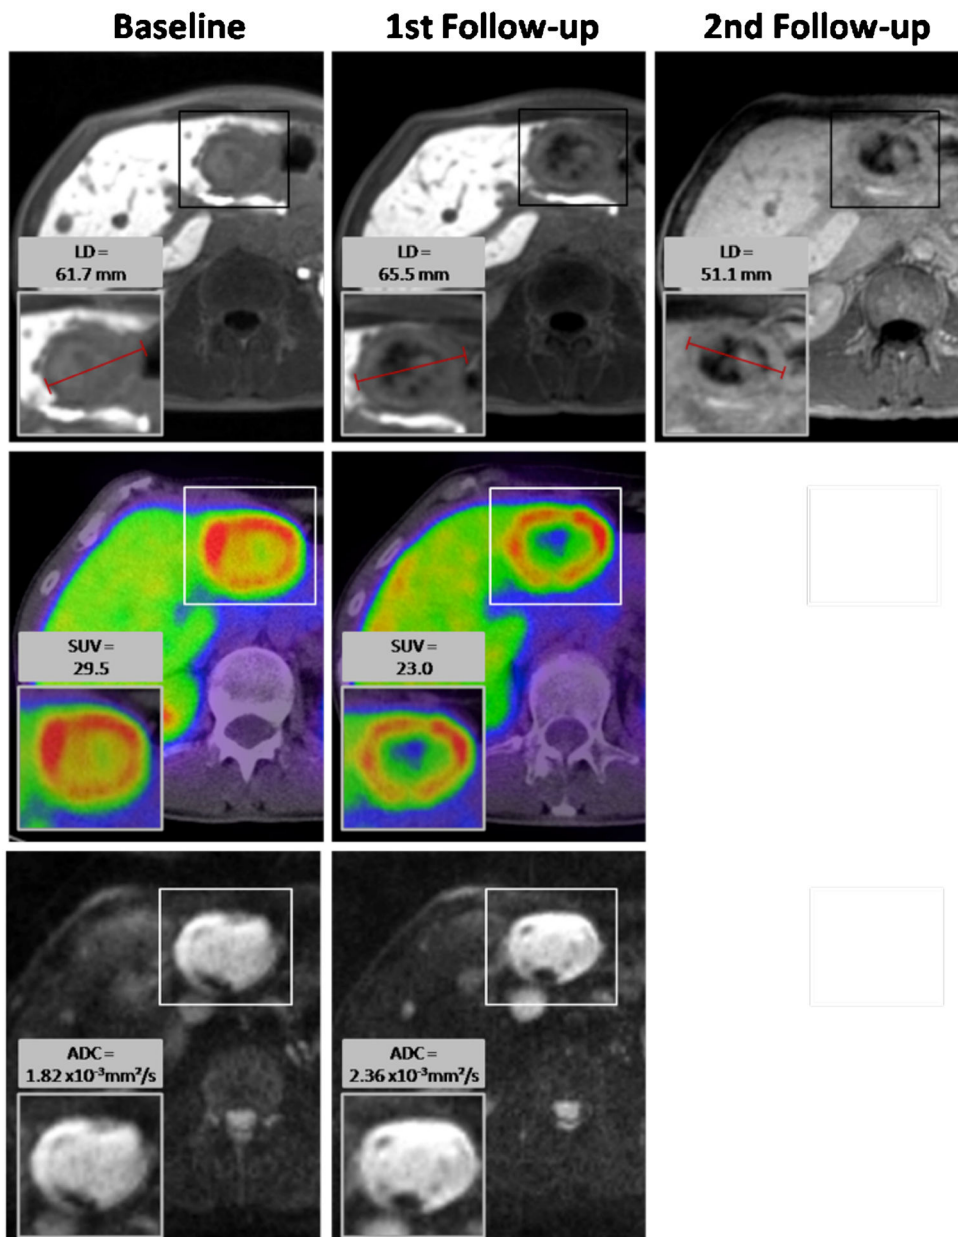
Neuroendocrine liver metastasis in a 44-year-old male. After one cycle of PRRT (first follow-up), the LD and the volume of the target lesion increased and it was thus categorized as nonresponding lesion. ADC_{mean} increased from 1.82×10^{-3} to $2.36 \times 10^{-3} \text{ mm}^2/\text{s}$. Remarkably, there was a decrease in maximal SUV of ^{68}Ga -DOTATOC in this first follow-up imaging from 29.5 to 23.0. To confirm if this decrease was followed by a later decline in LD and volume of the metastasis after further PRRT, a second follow-up examination was analyzed 11 months after baseline imaging. Here, the size of the target lesion had decreased below its baseline values.
